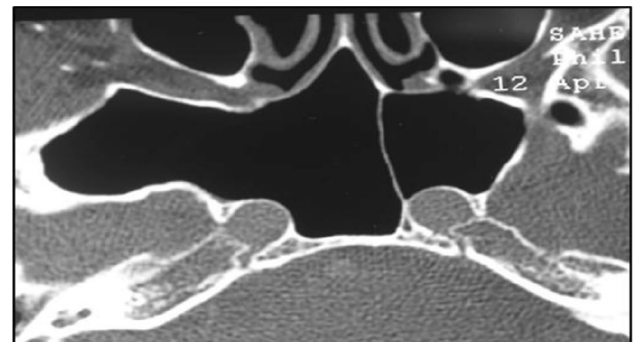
CT scan showing the insertion of the inter-sphenoid sinus septum on the internal carotid artery
